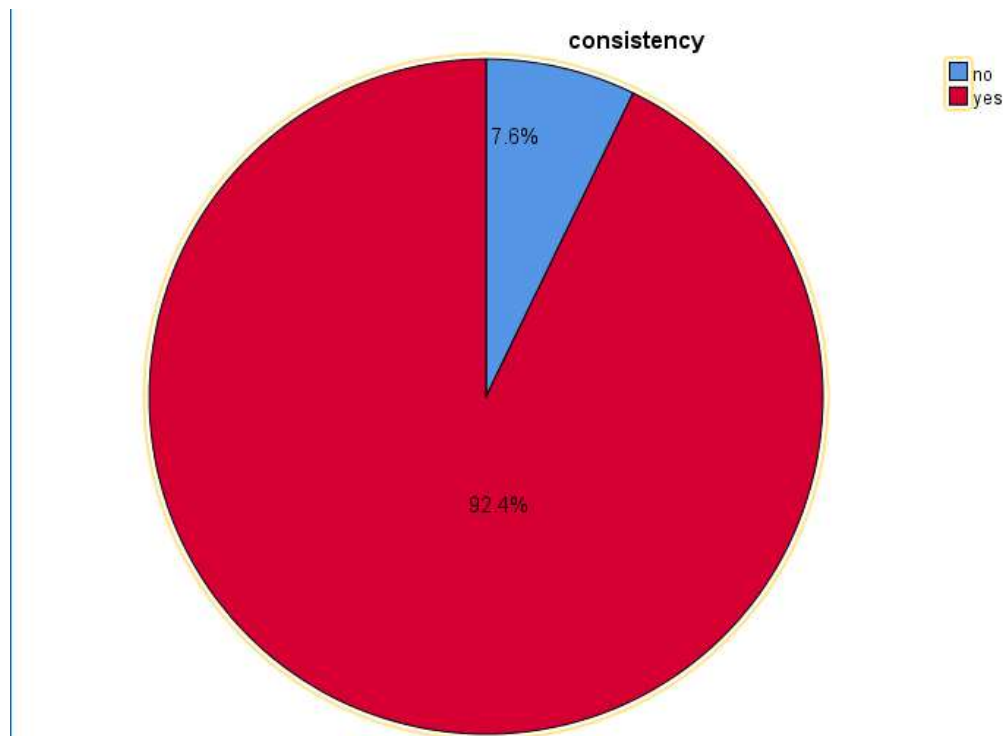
consistency of ultrasound and FNAC result in TGSB, Amhara region, North west Ethiopia, 2022. (n=250)
